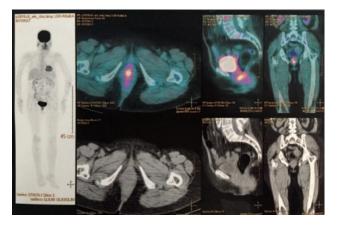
PET-CT shows metabolic activity at the level of the vagina.
